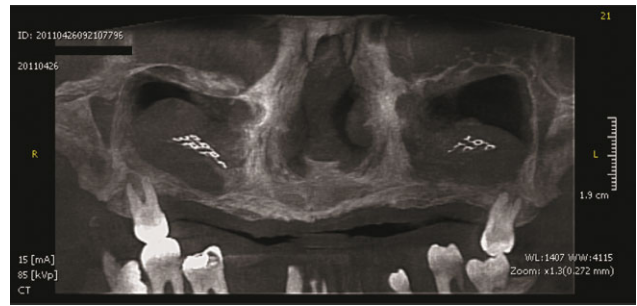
Reformatted panoramic view from immediate CBCT after the operation showing intrasinus hematoma surrounding the titanium mesh.
